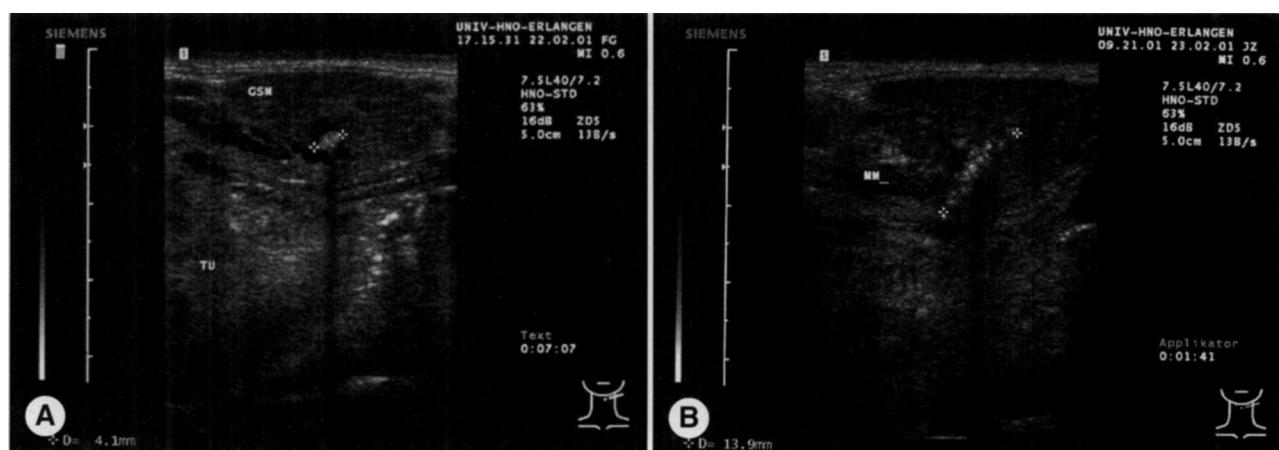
Ultrasonography. A) Stone (asterisks) within hilus of right submandibular gland (GSM) before extracorporeal shock wave lithotripsy. TU — tongue. B) Majority of patients show fragmentation of stone after extracorporeal shock wave lithotripsy. Fragments (asterisks) are located within main ducts and distributed along intraparenchymatous parts of salivary ducts. Fragments can be washed out completely or may stay inside duct for long period without causing problems. MM — mylohyoid muscle.
